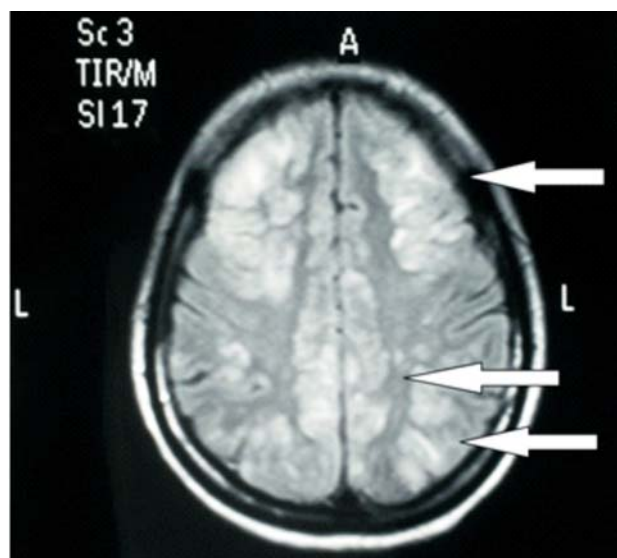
MRI Brain showing bilateral high signals in frontal, temporal, parietal and occipital lobes, lentiform nucleus, caudate nuclei (arrows) suggestive of PRES (posterior reversible encephalopathy syndrome).
